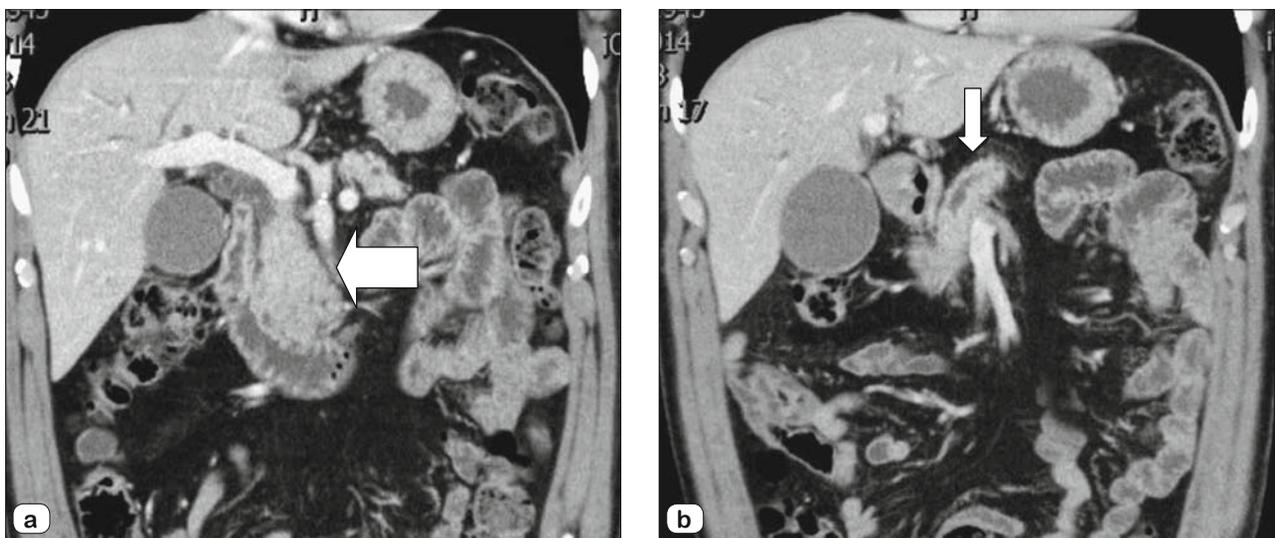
Coronal reconstruction contrast-enhanced CT images showed (a) enlargement of the pancreatic head (thick arrow) in comparison (b) to the atrophic pancreatic body with dilated pancreatic duct (thin arrow).
